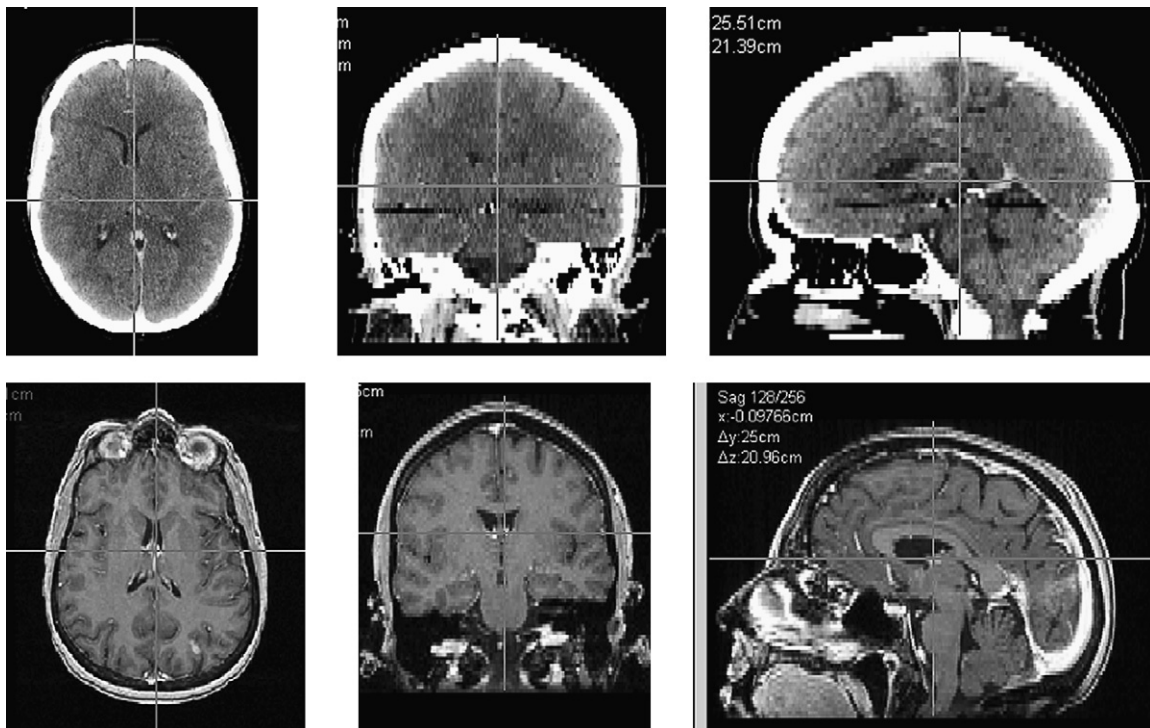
Transverse, coronal, and sagittal slices of the computed tomography and magnetic resonance imaging sets used for the registrations.
